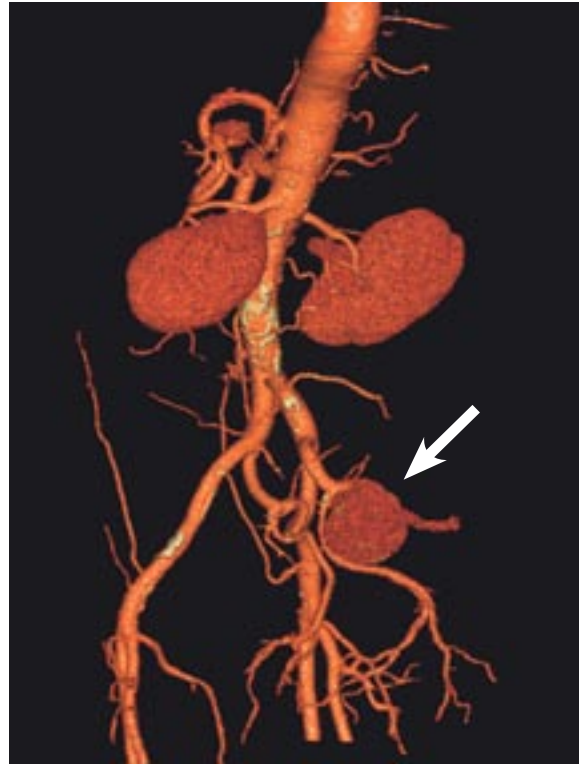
This 78-year-old male (history of hypertension, AV dysfunction, and prior pacemaker placement) presented with a several month history of bilateral leg edema. A CT of the abdomen and pelvis was done, showing a 4cm iliac artery pseudoaneurysm (arrow). Parameters: Brilliance CT 64-channel scanner; 6 sec scan time, 228mm scan length, 0.9mm slice thickness, 0.45mm slice increment. Essence technology: Smart Focal Spot, COBRA, Nano-Panel detectors.
